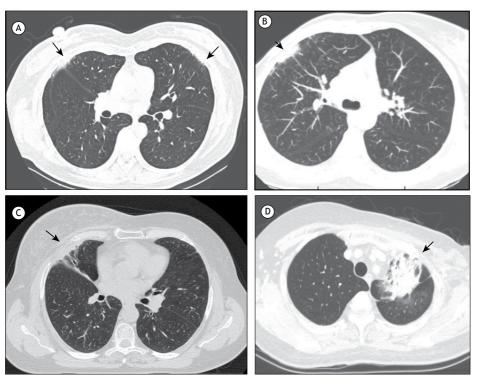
HRCT scans showing features of radiation pneumonitis. In A, HRCT scan scored as 1 in a patient submitted to bilateral treatment. In, B, C, and D, respectively, HRCT scans scored as 2, 3, and 5..
